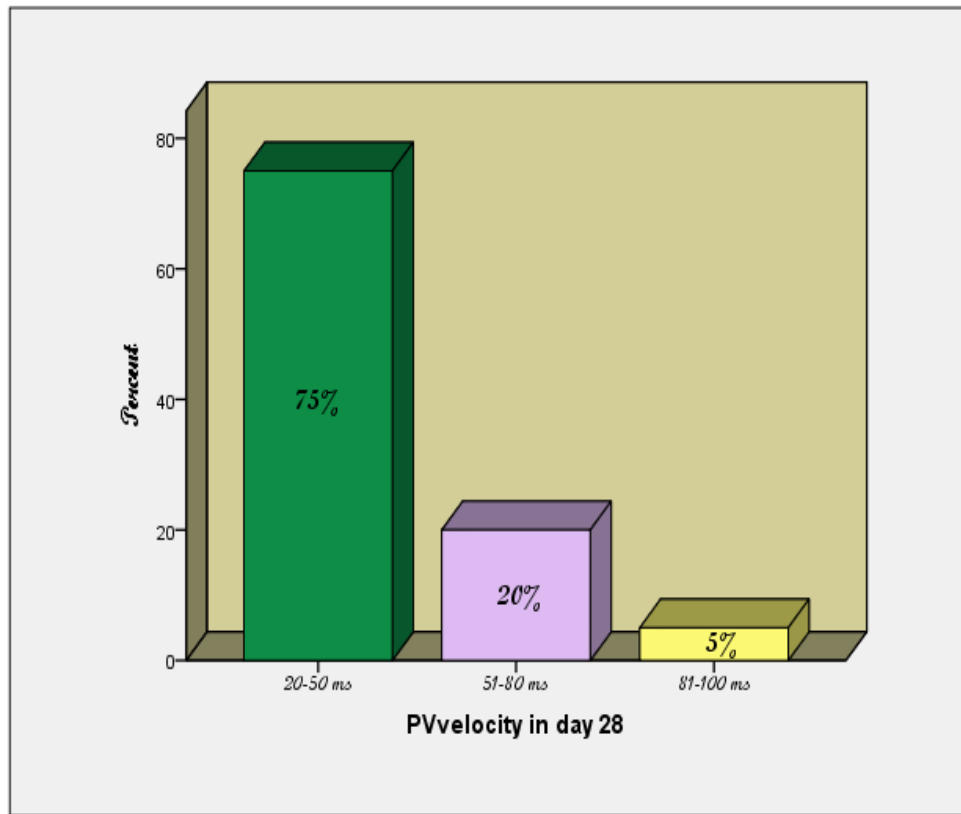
Frequency distribution of spectral Doppler for portal vein in day 28
